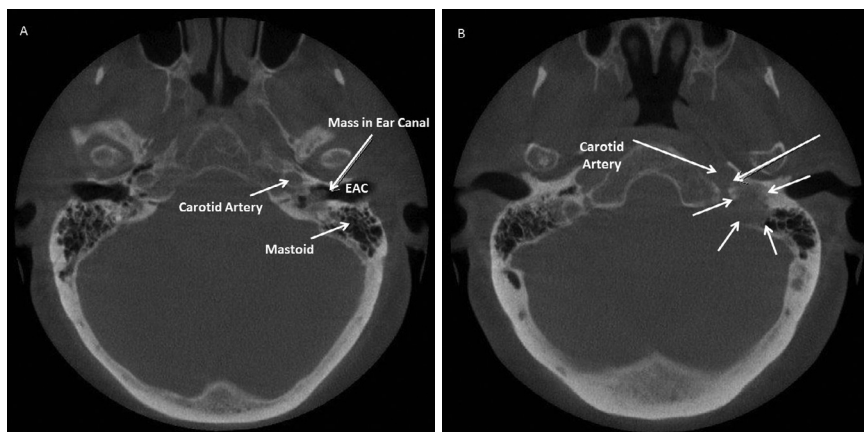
Axial CT of the temporal bone demonstrating (A) mass into the ear canal and (B) destruction around the jugular bulb (short arrows) and extension of the mass to the carotid artery (long arrow).
